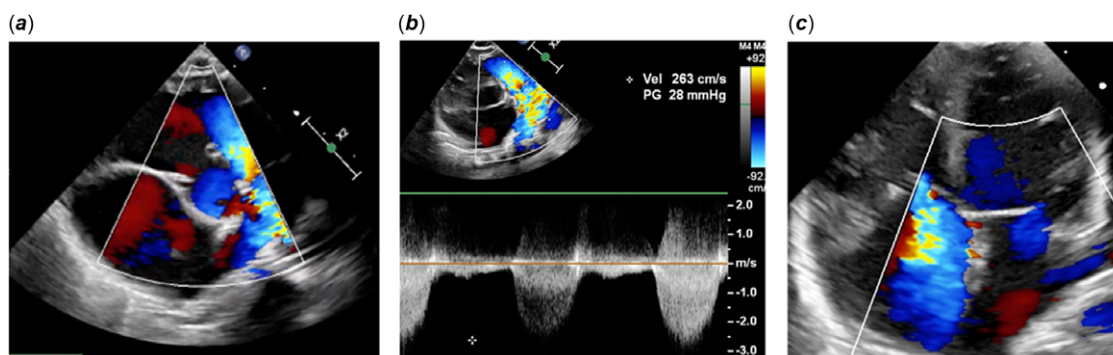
Echocardiogram reveals (a) ventricular septal defect, (b) right ventricular outflow tract stenosis, and (c) severe tricuspid regurgitation. Besides these figures, the echocardiogram also shows atrial septal defect and patent ductal arteriosus.
